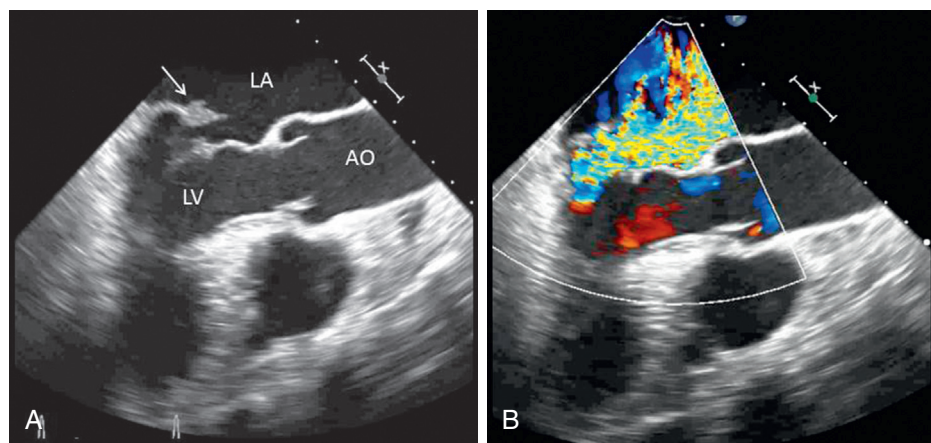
■ Two-dimensional transesophageal echocardiogram (A) in a 72-year-old male with known mitral valve prolapse; ruptured chordae resulted in flail of the mitral posterior leaflet (arrow) and acute worsening of symptoms. Color Doppler (B) shows severe eccentric mitral regurgitation with a mosaic pattern through the noncoapting mitral valve. AO, aorta; LA, left atrium; LV, left ventricle.
